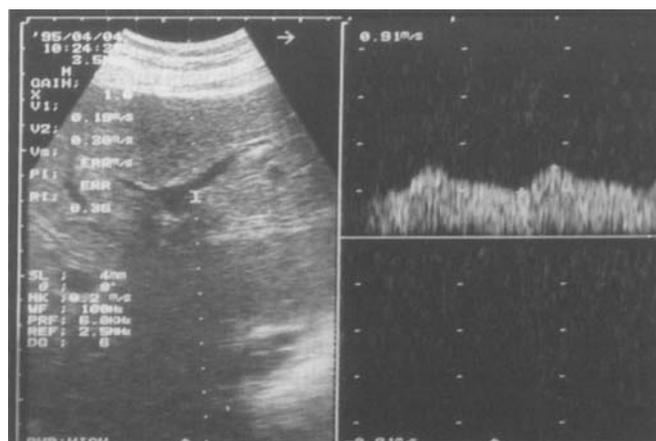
Hepatic artery stenosis a few months after orthotopic liver transplantation. Echodoppler examination shows perturbed parameters in the distal hepatic arteries (resistive index = 0.36, systolic acceleration time = 0.14 s)
